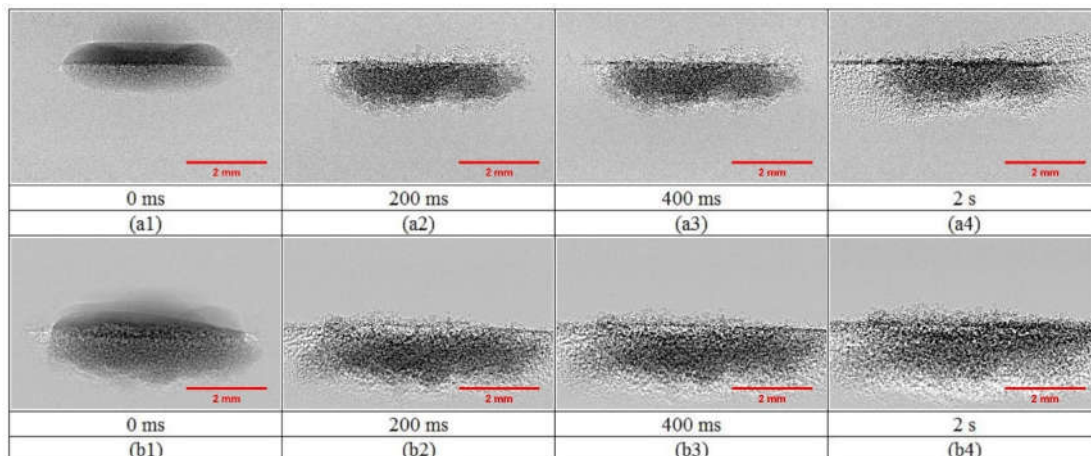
The time sequence X-ray images of the granulation process of MCC powder with water as a liquid binder released from 2.5 cm at volumes of (a1-a4) 10 μl and (b1-b4) 15 μl .
